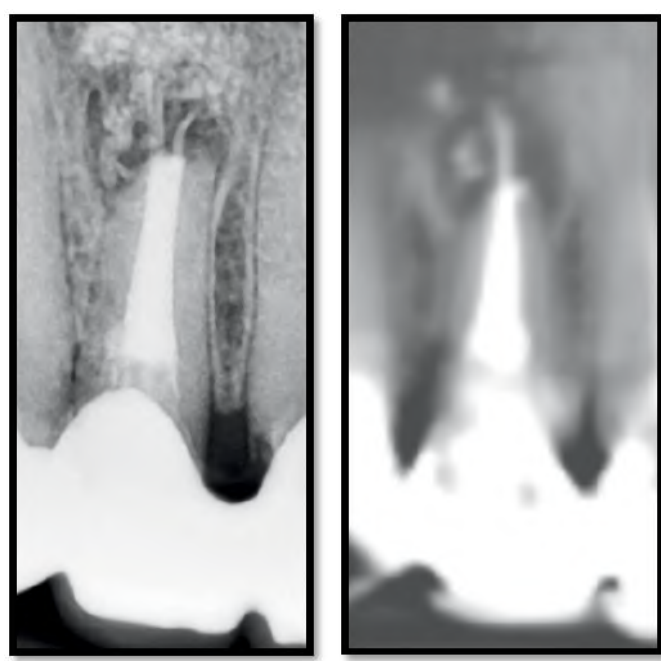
Pre-operative X-Ray and CBCT image showing persisting apical lesion after two apicoectomies.
